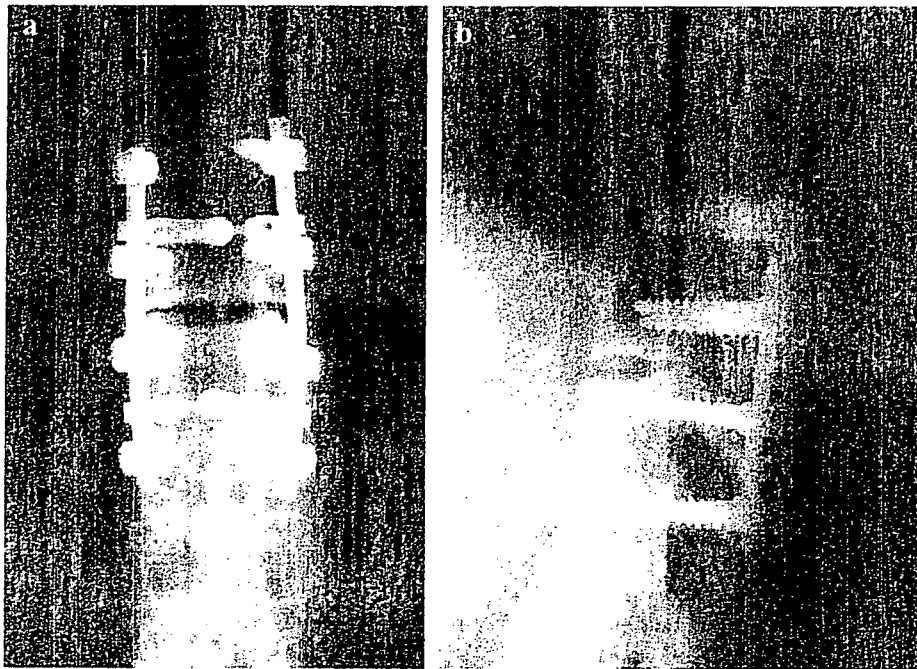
Postoperative radiographs of the thoracolumbar spine. After laminectomy of T11 and T12, posterolateral fusion from T10 to L1 was performed using a pedicle screw system. (a) Anteroposterior view. (b) Lateral view.
